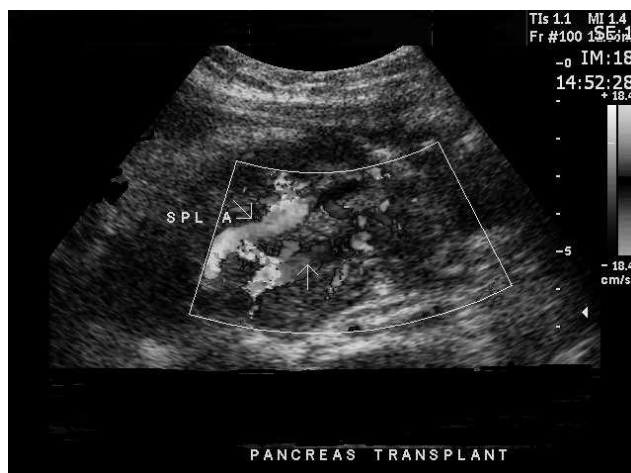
Pancreatic transplant visualized with color-flow Doppler imaging, demonstrating the patent splenic artery and vein.
